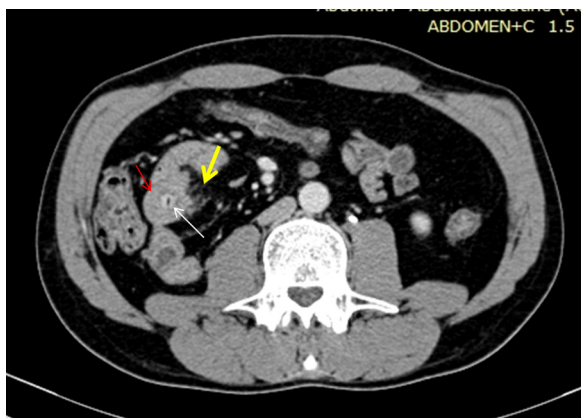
Axial CT scan after contrast administration showing wall thickening of the jejunum which was abnormally on the right (red arrow). The tumor was narrowing the jejunal lumen; total obstruction was a result of a bezoar (white arrow). Mesenteric limits of the tumor are ill defined with fat densification (yellow arrow).
